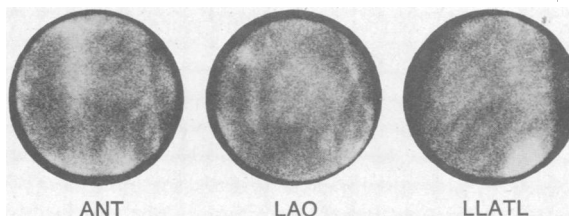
Diffuse uptake. The TcPYP scintigram showing diffuse accumulation of the radionuclide in a patient with an acute subendocardial infarction. (From Prasquier R, et al: *Circulation* 55:61-66, 1977.⁵¹ With permission of the authors and the American Heart Association.)
